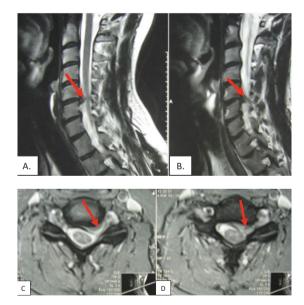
A-B)* Sagittal MRI (14/04/2016): C5-C6 subligamentous disc herniation (arrows), survey carried before treatment, on the date of the treatment. *C-D) Axial MRI (14/04/2016): C5-C6 sub-ligamentous disc herniation (arrows), a survey carried out before treatment and on the date of the treatment.*
